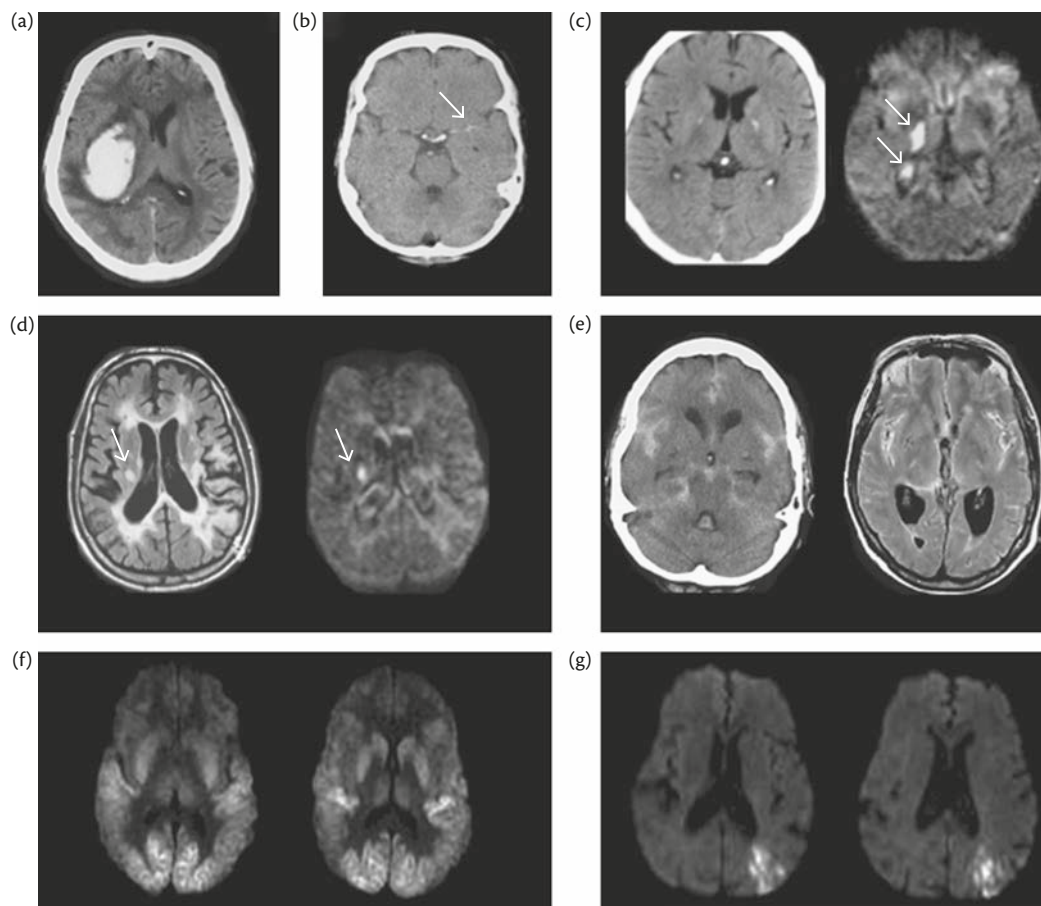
(a) CT scan of acute intracranial haemorrhage. The CT image shows hyperdense acute haemorrhage in the basal nuclei–corona radiata on the right, along with surrounding hypodense oedema. (b) Early hyperdensity on a CT scan of the left middle cerebral artery (indicated by arrow). (c) CT scan (left) and MRI (right) of acute ischaemia. The image on the right shows high sensitivity of MRI DWI in the acute phase of ischaemia (visible as hyperintensity in DWI sequences); the acute ischaemia is not evident on the CT scan (left). (d) DWI sequence is useful to differentiate new ischaemic lesions (arrow—more evident on right image), not easily discernable on a FLAIR image (left image). (e) Acute SAH is better seen on a CT scan (left) than MRI (right). (f) Widespread hyperintensity on DWI in hypoxia (most affected are the cortex and basal nuclei). (g) Boundary zone hyperintensity on DWI in hypoperfusion.
